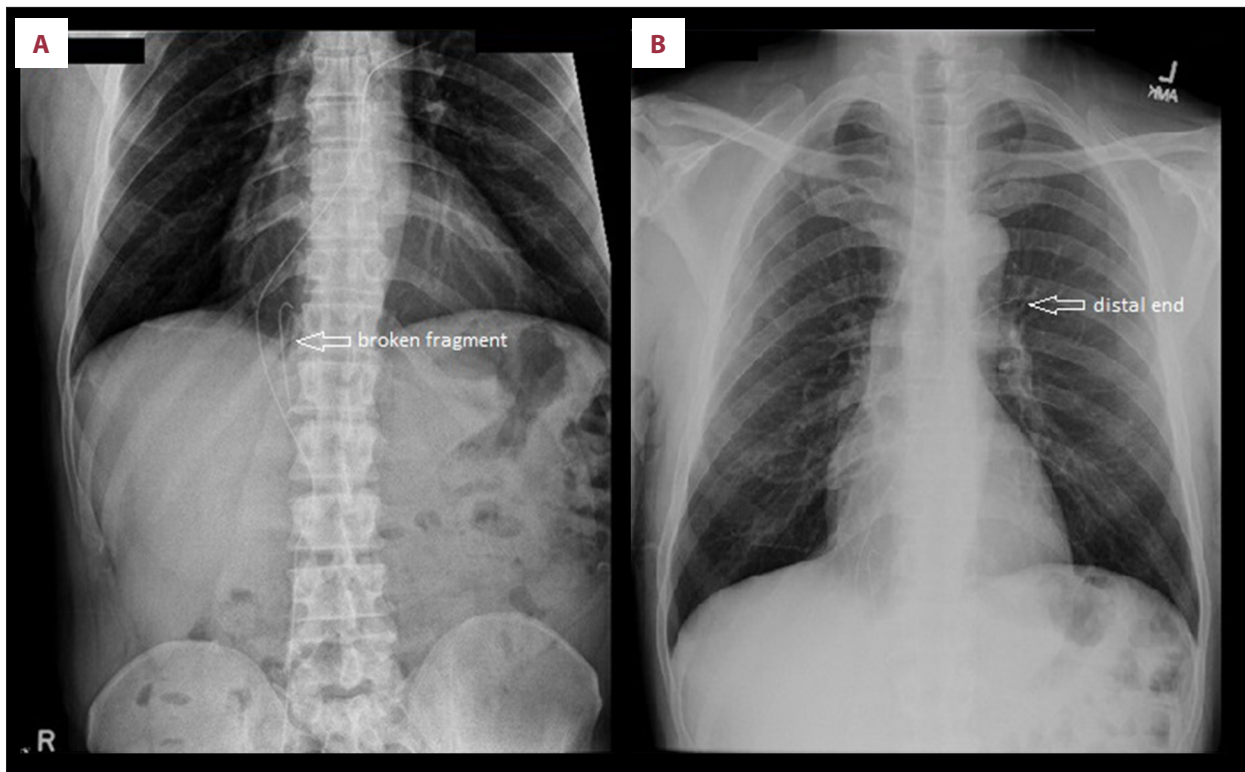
Abdominal and chest X-radiographs of a 52-year-old African-American man who presented with a retained venous guidewire. Abdominal (A) and chest X-radiographs (B) showing the guidewire extending upwards along the right paravertebral area to the level of the heart, ending in the left hilar area (arrow). A broken hook-like fragment is shown at the level of the diaphragm (arrow).
